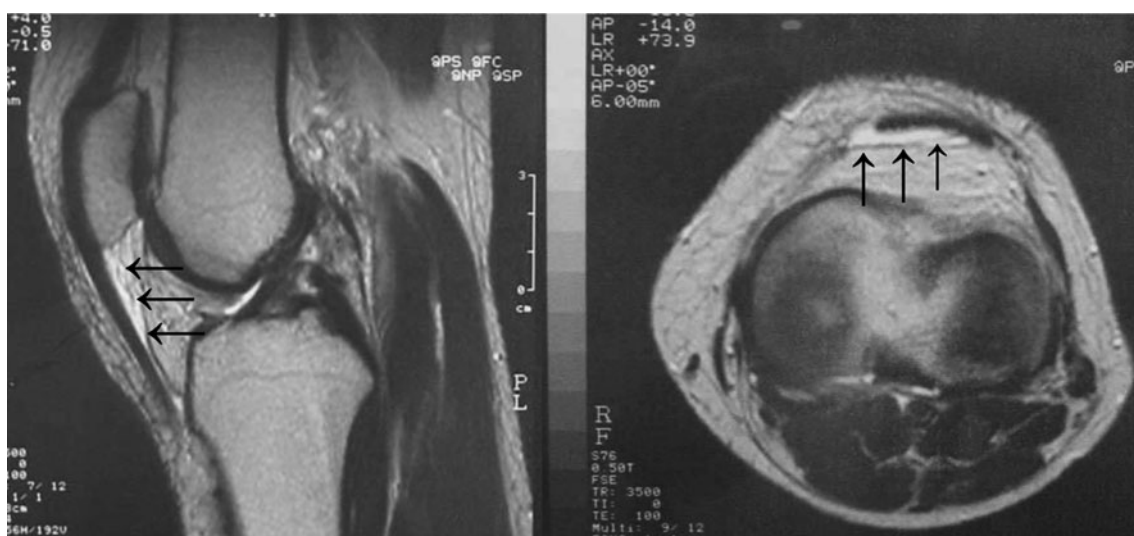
Magnetic resonance images of the knee of a patient with patellar tendinopathy 4 h after hyaluronan injection. Both sagittal and transverse images reveal a high-intensity area between the patellar tendon and the infrapatellar fat pad, which indicates the presence of hyaluronan
